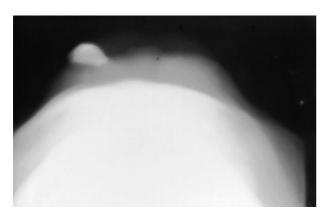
The preoperative axial X-ray of the soft tissues showed a radiopaque image included in the lower lip tissues.
